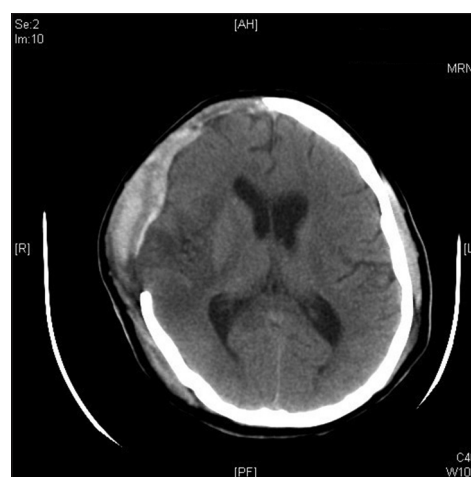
Postoperative computed tomography of brain after 3 days showing resolution of the mass effect with no midline shift
